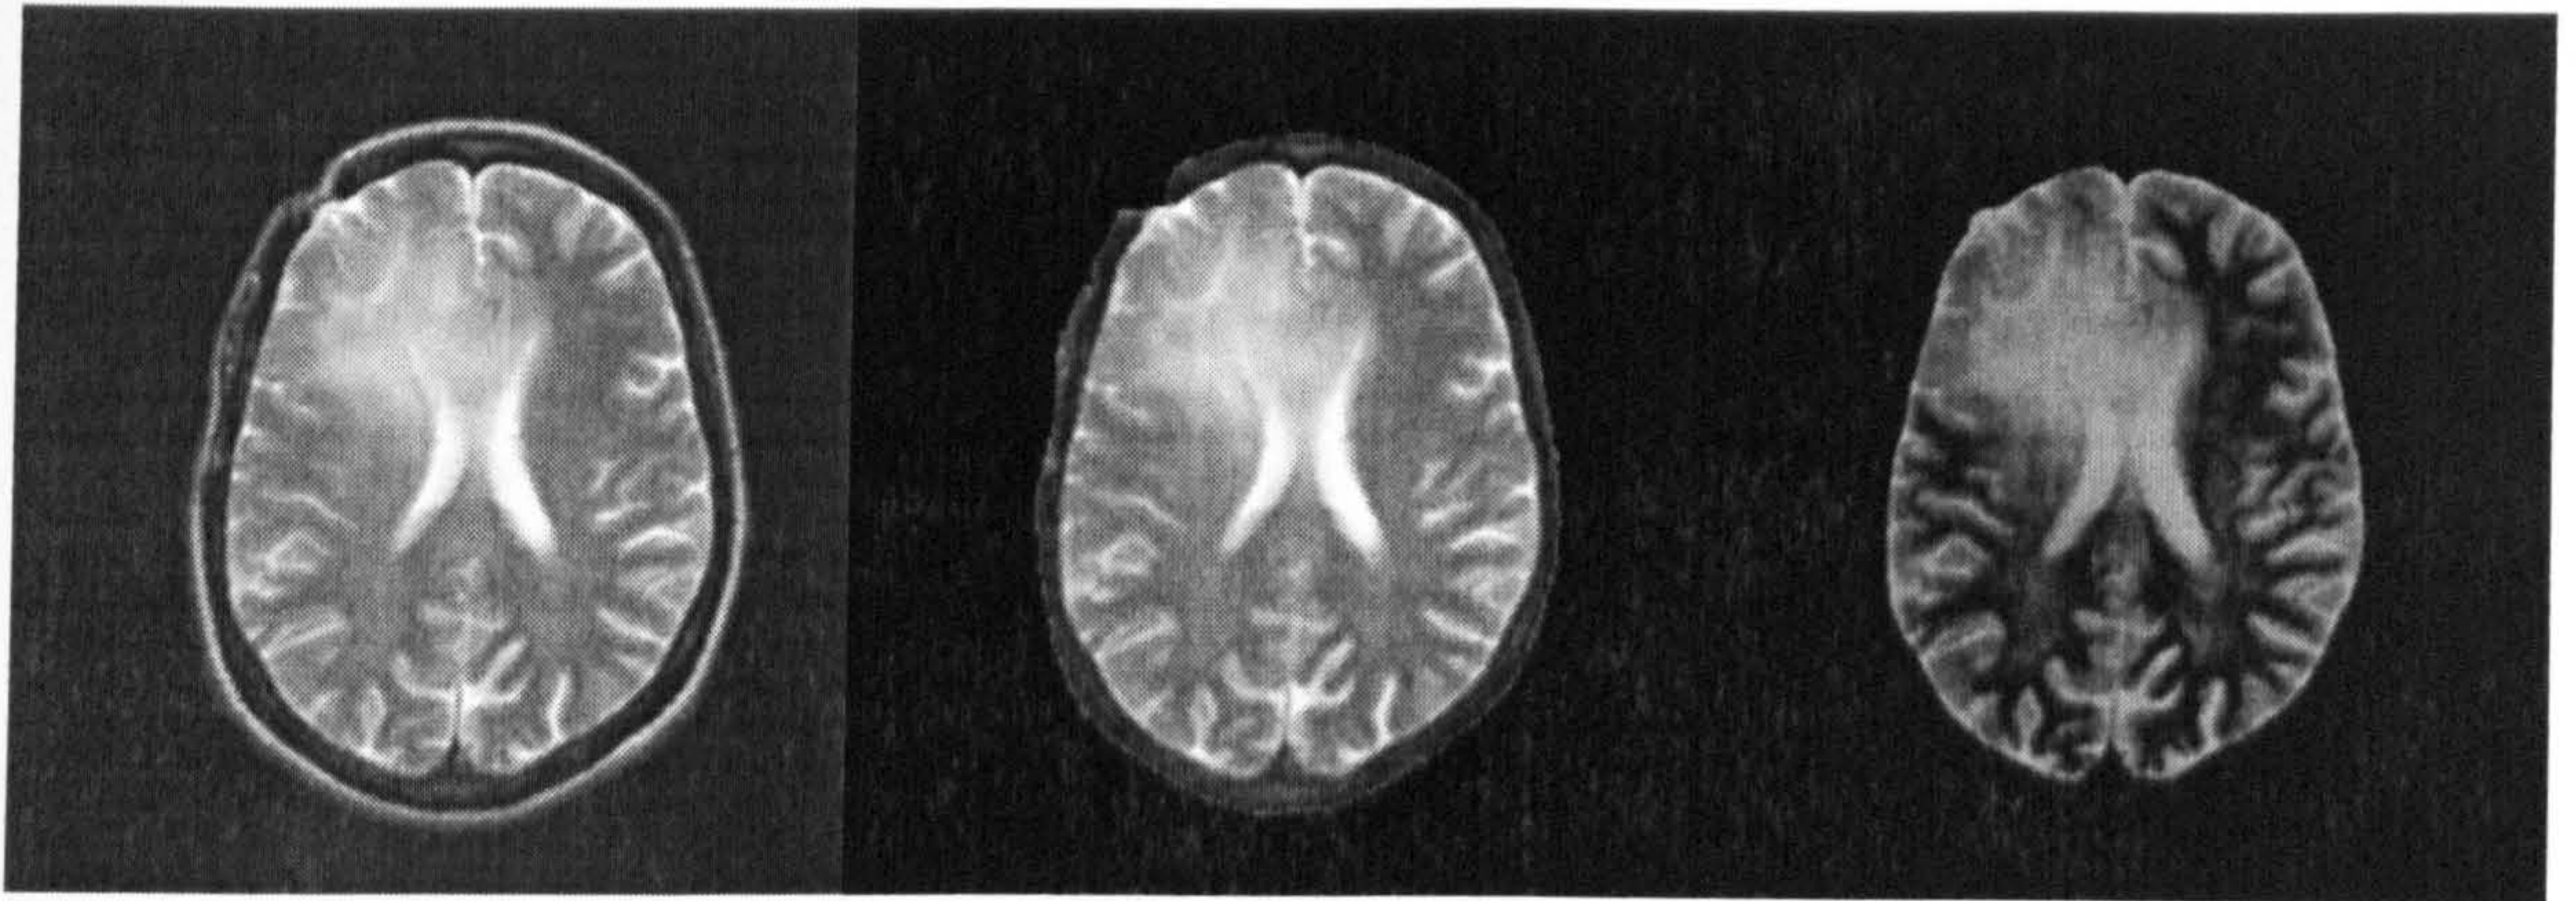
Preprocessing and segmentation of T_1 -SE MR image.
